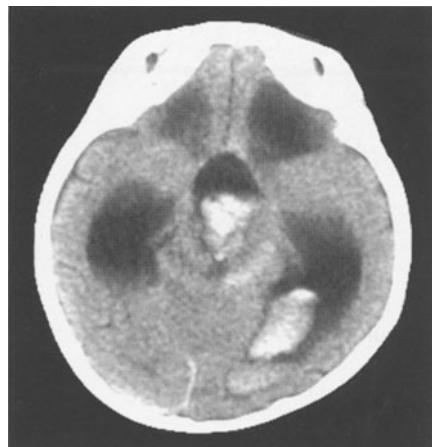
Postoperative CT of a child who had an ETV complicated by intraoperative hemorrhage. It occurred at the time of the ventriculocisternostomy
